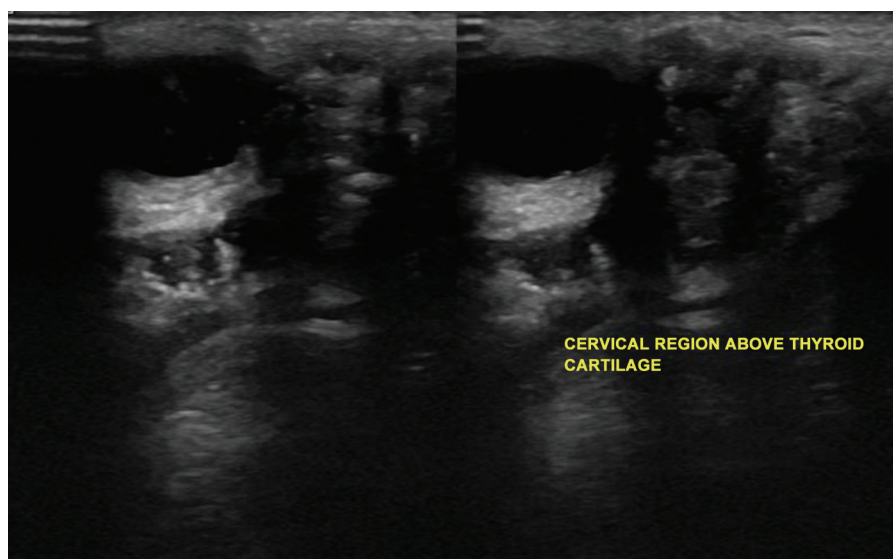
Neck ultrasound scan, with a solid-cystic nodule located in the midline, inferior to the hyoid bone, presenting internal calcifications and measuring approximately 3.6 cm.
